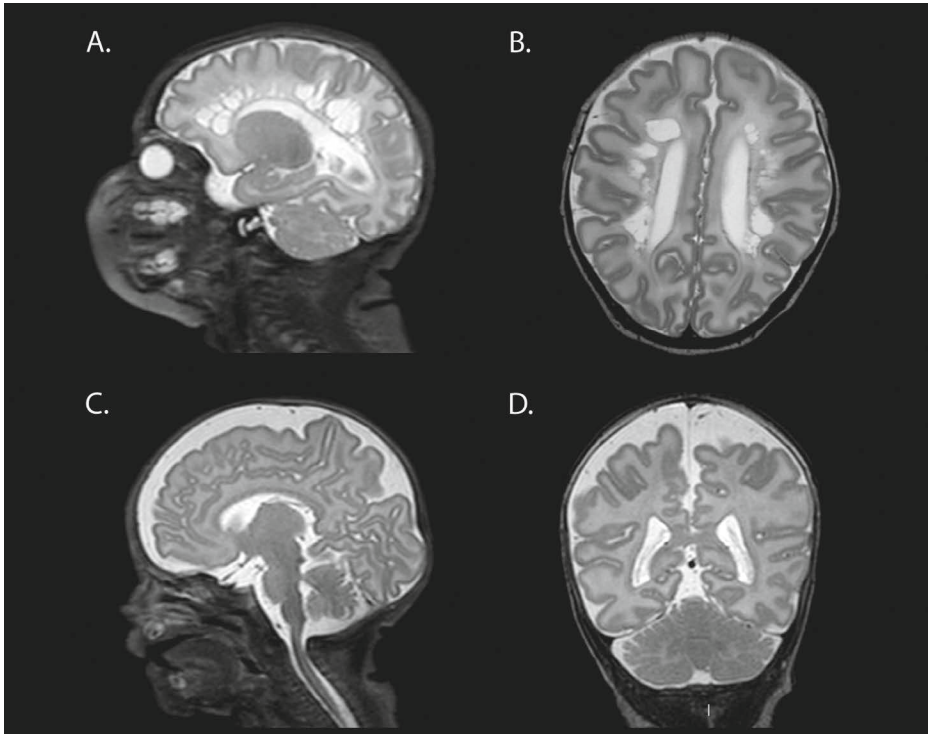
Two types of white matter injury in the preterm neonate as demonstrated on T2-weighted MRI scans at term-equivalent age (TEA). A/B. Cystic periventricular leukomalacia, with formation of large cysts in the white matter, viewed in the sagittal (A) and axial (B) plane. The incidence and severity of cPVL has decreased considerably in the last decades. C/D. The most prevalent type of white matter injury in the preterm brain: diffuse white matter injury (dWMI), with diffuse white matter atrophy, mild ventriculomegaly, thinning of the corpus callosum and global volume reduction, viewed in a sagittal (C) and coronal (D) plane.
